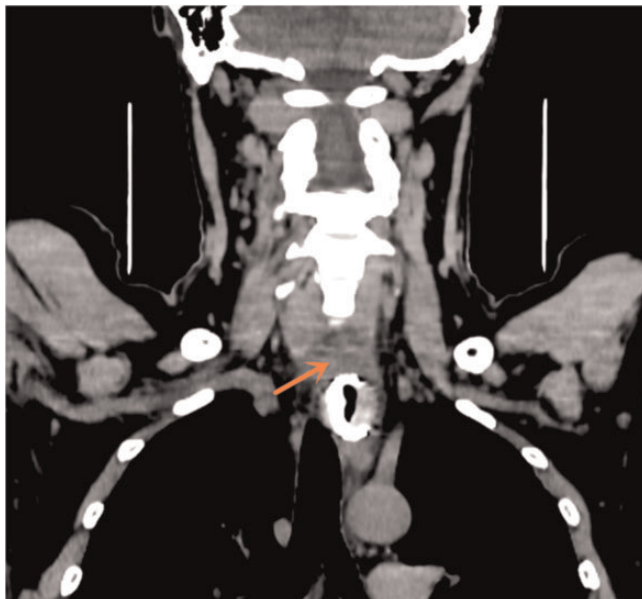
Computed tomography scan of the esophagus showing a foreign object in the esophageal lumen with the hypertrophy of the surrounding esophageal wall and ambiguous peripheral fat gap (arrow).
